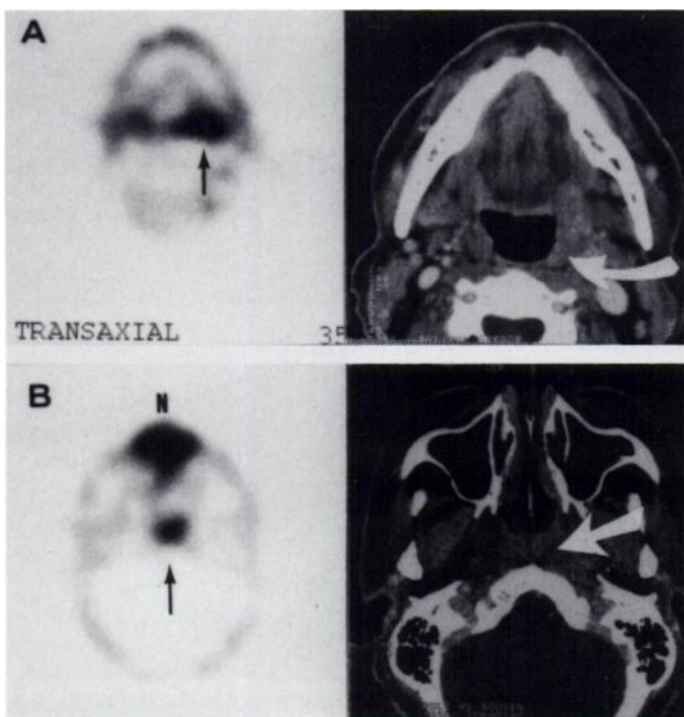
Transaxial SPECT images show increased ^{201}Tl uptake (black arrows) in (A, left) a T1 carcinoma of the oropharynx and (B, left) a T2 carcinoma of the nasopharynx in two patients presenting with neck metastases of unknown origin. On the right, enhanced CT shows only a slight asymmetry of left tonsillar region (curved white arrow on A), and unenhanced CT shows no abnormalities in the nasopharynx (straight white arrow on B). (B) Nasal activity (N) is also seen on SPECT images.
